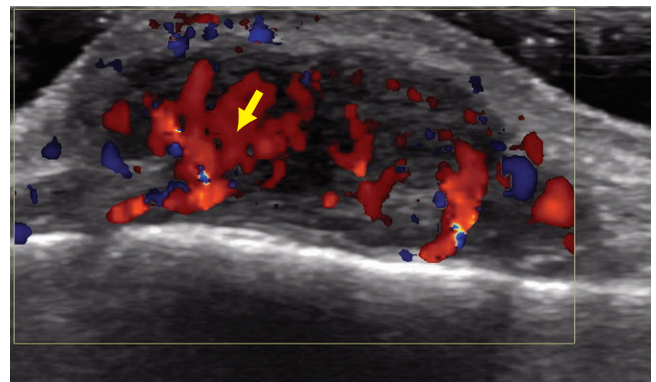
The sagittal image of the flexor side of the thumb shows increased color Doppler flow within the giant cell tumor (arrow).
